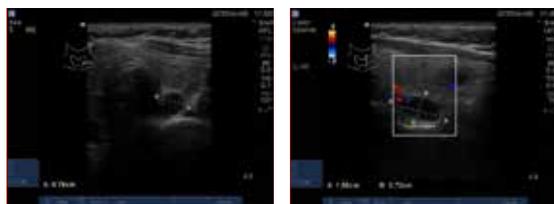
Surgeon performed ultrasound demonstrating a left parathyroid adenoma behind the lower pole of the thyroid
